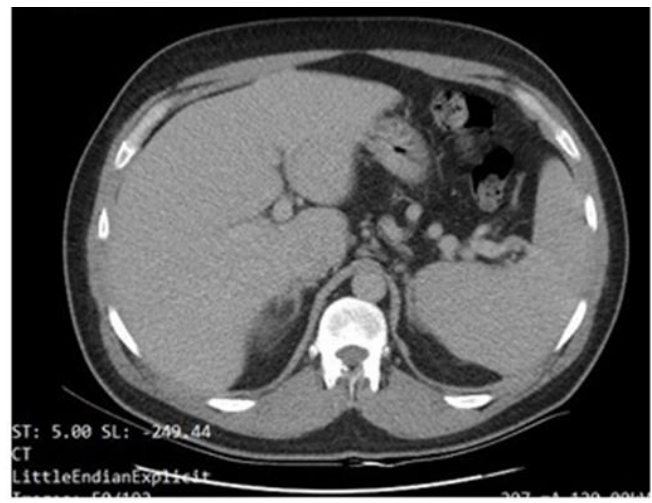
CT abdomen and pelvis
